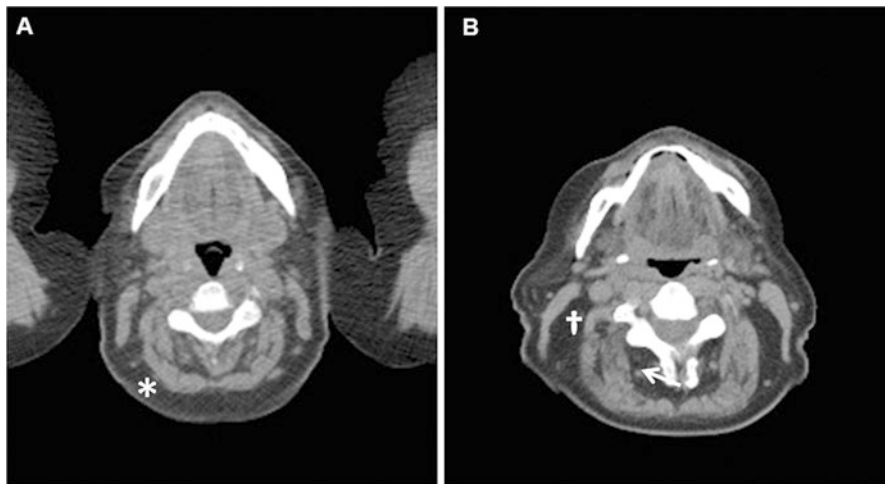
CT of the neck for assessment of neck adipose tissue (NAT) in a 56-year-old woman and a 56-year-old man with the same BMI (35 kg/m²). The woman had more subcutaneous NAT (*asterisk*), and the man had more intermuscular adipose tissue [posterior NAT (*cross*) and perivertebral NAT (*arrow*)]. The man but not the woman had serum measures consistent with the metabolic syndrome
